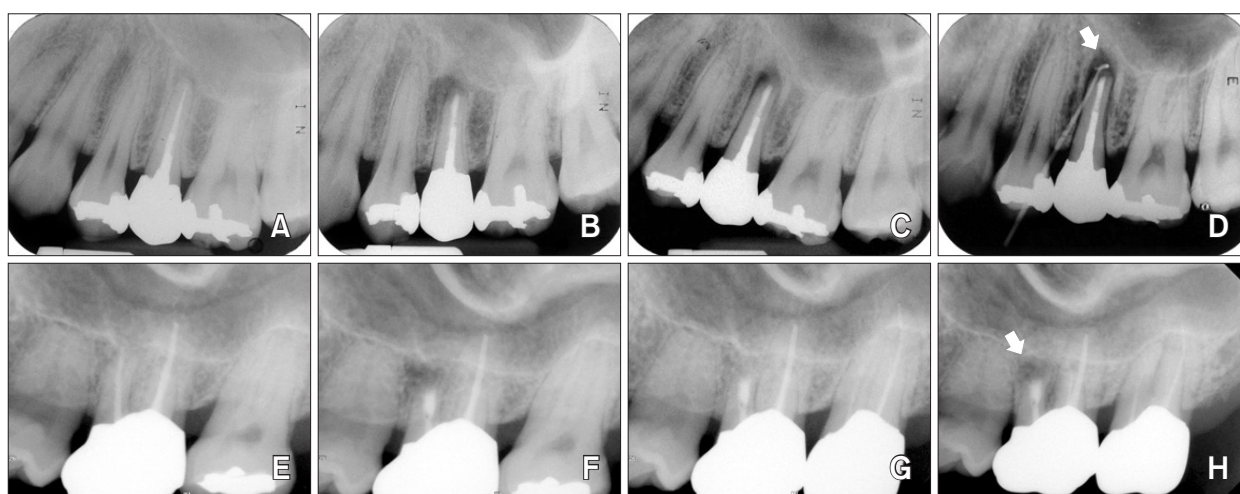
Failed cases with sinus perforation. (A~D) Case of left maxillary second premolar. (A) Preoperative radiograph. (B) Postoperative radiograph. (C) Six-month follow-up radiograph. (D) Twelve-month follow-up radiograph with gutta-percha cone tracing through sinus tract. Note that periapical radiolucency had recurred (arrow). (E~H) Case of left maxillary first molar. (E) Preoperative radiograph. (F) Postoperative radiograph. (G) Eighteen-month follow-up radiograph. (H) Six-year follow-up radiograph. Periapical radiolucency on mesiobuccal root was detected (arrow).
